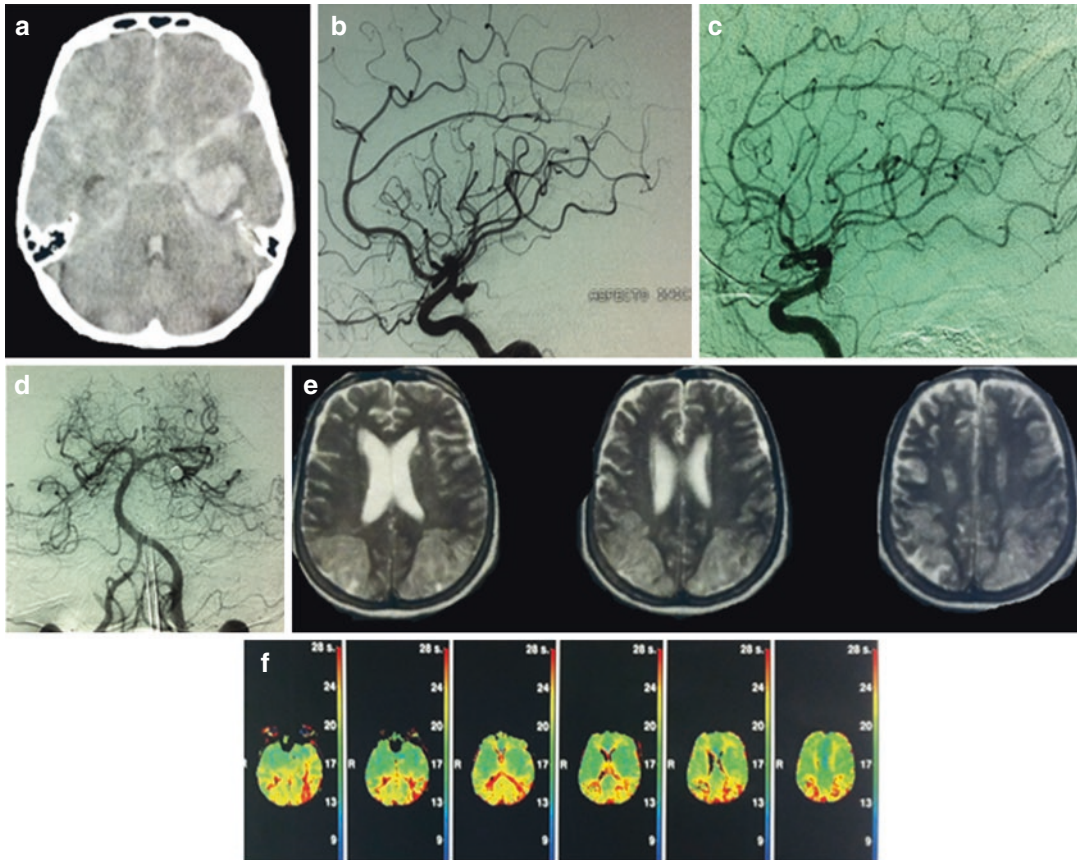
This 72-year-old female patient with a typical history of sudden headache associated with disorientation (HH III) was admitted to hospital. (a) CT scan showed a Fisher III with medial temporal hematoma. (b) Angiography performed 24 h after admission confirmed an ICA-PCoM aneurysm, which was coiled. The patient did well until the ninth day after bleeding, when she became drowsy and unresponsive. (c) and (d) Angiography
